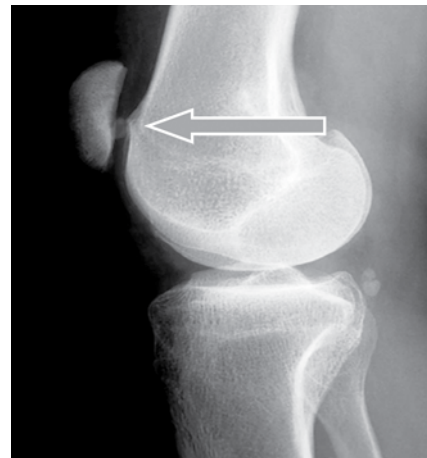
Trochlear dysplasia (X-Ray).
